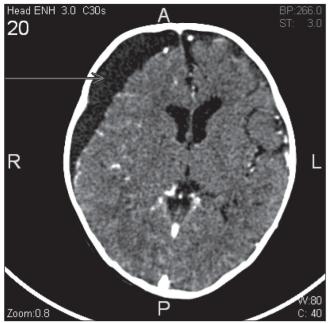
A computed tomography scan of the head showing a 1.2 cm extra-axial fluid collection with a 6 mm leftward midline shift
